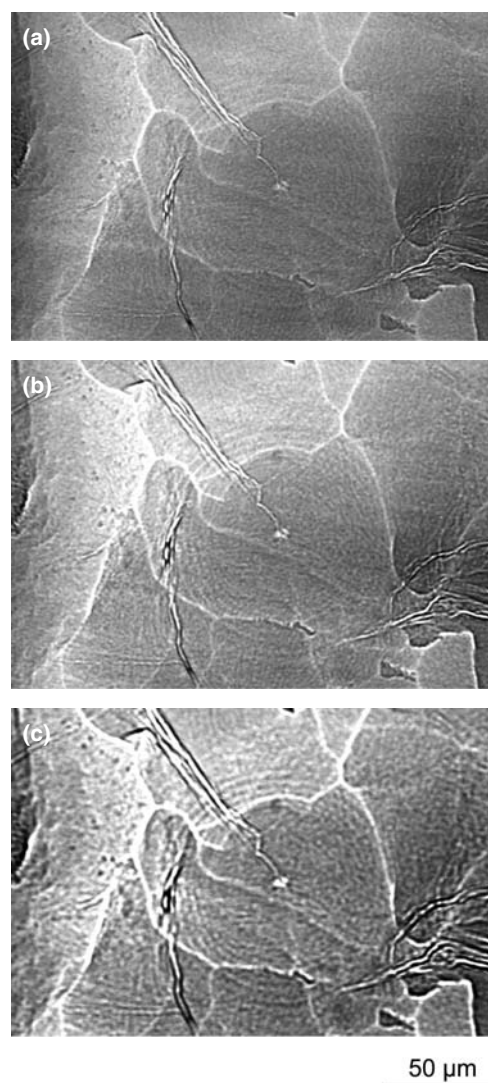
The three micro-radiographs show a detail of the otolith. The images only differ in the sample-to-detector distance  $L_2$  used in the acquisition (A:  $L_2 = 5 \text{ mm}$ , B:  $L_2 = 15 \text{ mm}$ , C:  $L_2 = 35 \text{ mm}$ ). It can be clearly seen that with increasing distance the spatial resolution becomes poorer but the contrast increases.
